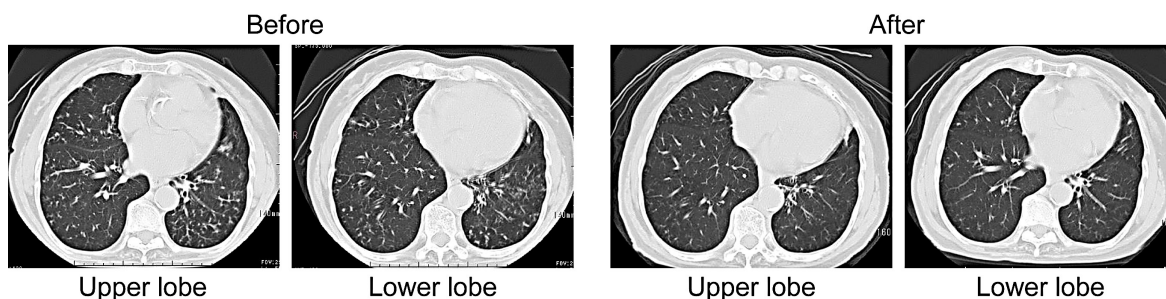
Chest CT findings before and after ANK.
